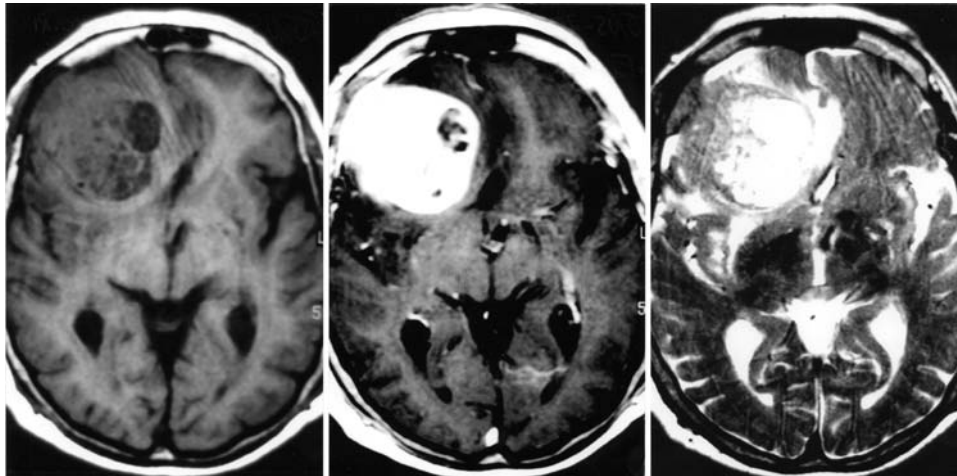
Axial T₁-weighted MR images without (*left*) and with (*center*) Gd enhancement demonstrating an extraaxial mass. *Right*: Axial T₂-weighted MR image.
